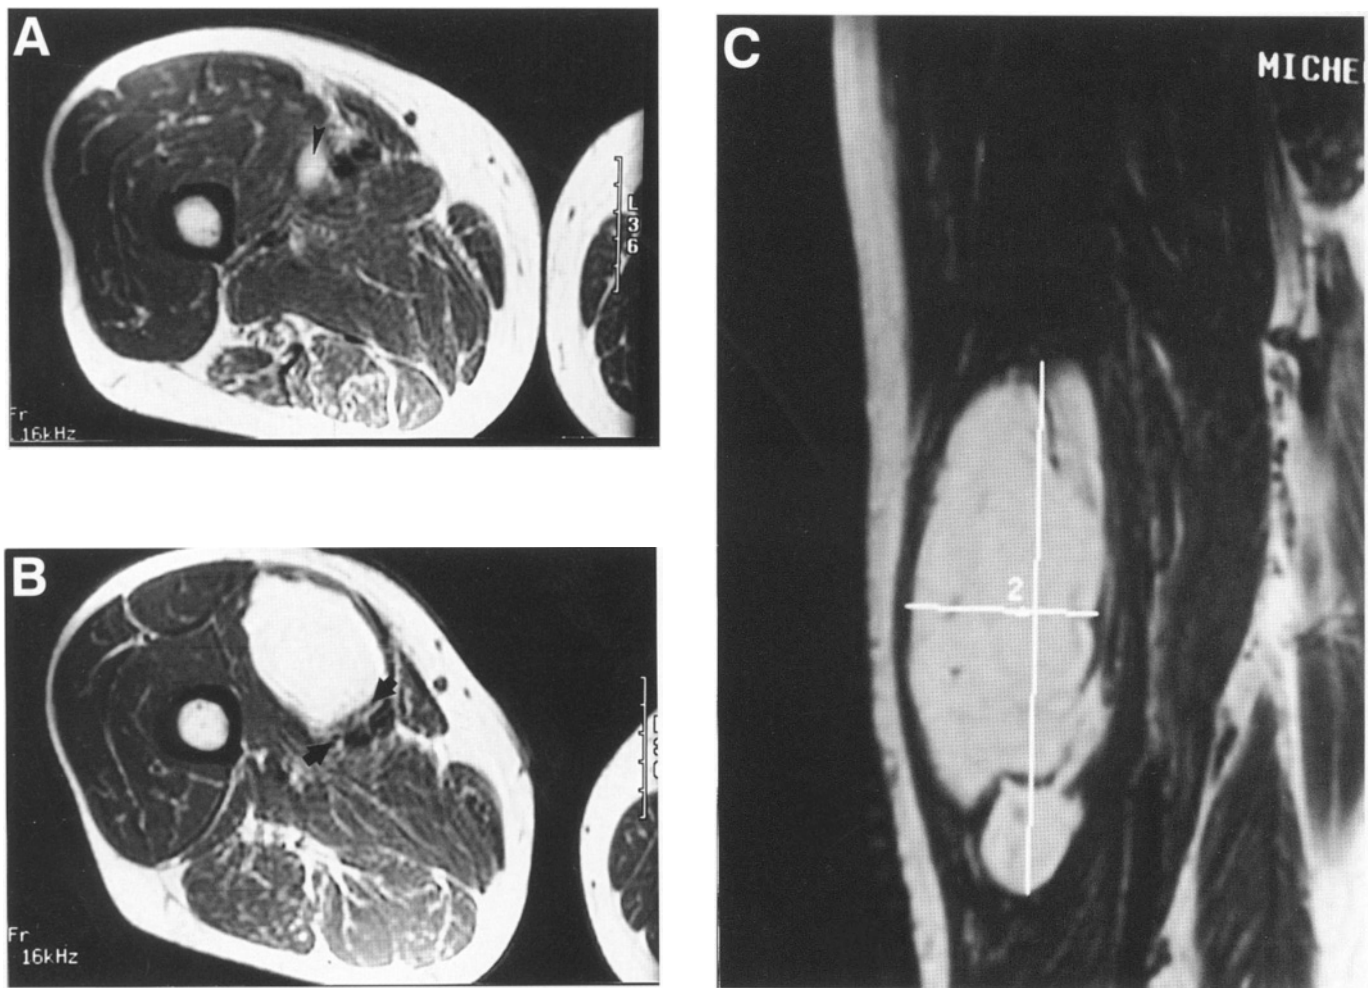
MRI evaluation of a quadriceps mass. (A) Axial T1 weighted image. Note the small tumor of the inferior aspect of the vastus medialis adjacent to the superficial femoral artery and vein (small arrow). (B) Axial T1 weighted image of the same patient shows large tumor involvement of the vastus medialis muscle but it is separated from the superficial femoral artery and vein (sartorial canal) by a thick fascial border of the vastus medialis (solid arrows). This fascial usually provides a safe resection margin. (C) Sagittal image of the same tumor (low to intermediate grade liposarcoma) showing almost a separate tumor with a small connection to the primary mass. Liposarcomas characteristically may have multiple lesions within the same muscle belly.
